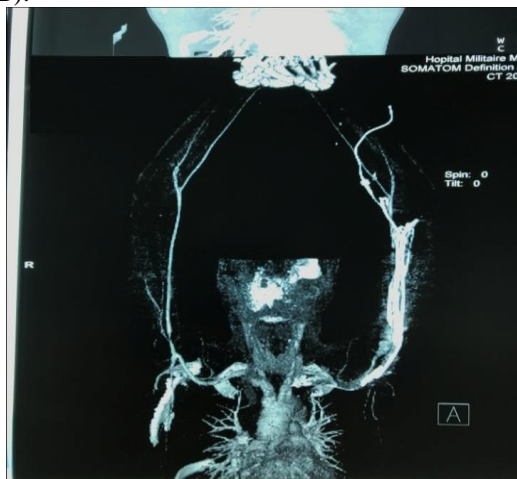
CT angiography: axillary aneurysm of left upper limb.
